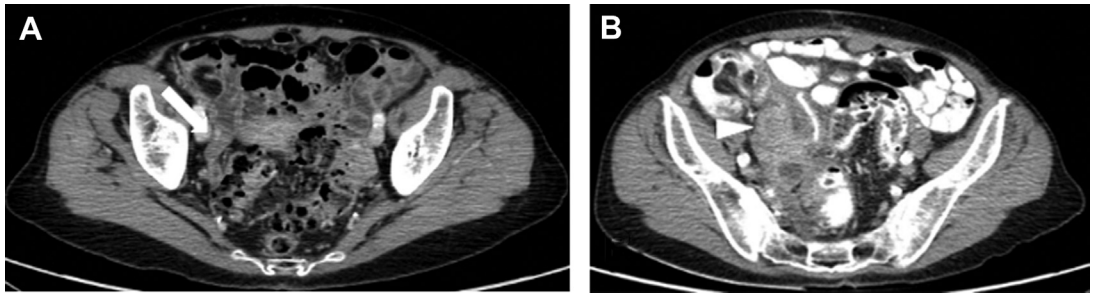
Incidental appendiceal cancer. A 69-year-old woman with weight loss. Axial intravenous contrast-enhanced CT image (A) of the abdomen and pelvis demonstrates a subtle mass at the base of the appendix, which was overlooked by the interpreting radiologist (arrow). Two years later, the mass has increased in size (B [arrow-head]). The patient underwent right hemicolectomy with pathology revealing adenocarcinoma.
